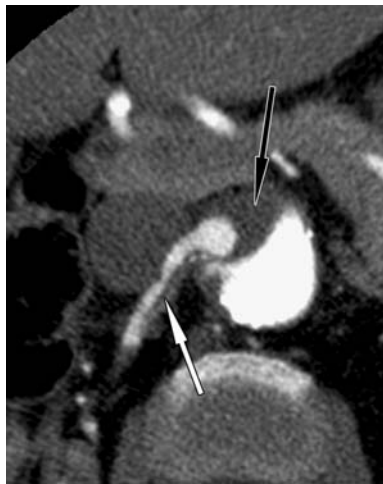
Axial contrast-enhanced CT image of aortic dissection with largely thrombosed false lumen (black arrow) and extension of the dissection into the right renal artery. The white arrow indicates the dissection flap in the right renal artery. There was diminished perfusion of the right kidney (not shown).
